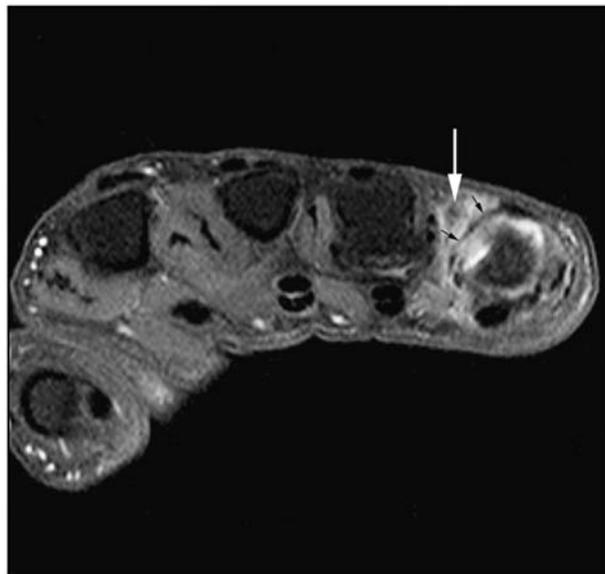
Axial T1 MRI with contrast showing radial collateral ligament (white arrow) superficial to the radial sagittal band (black arrows).
